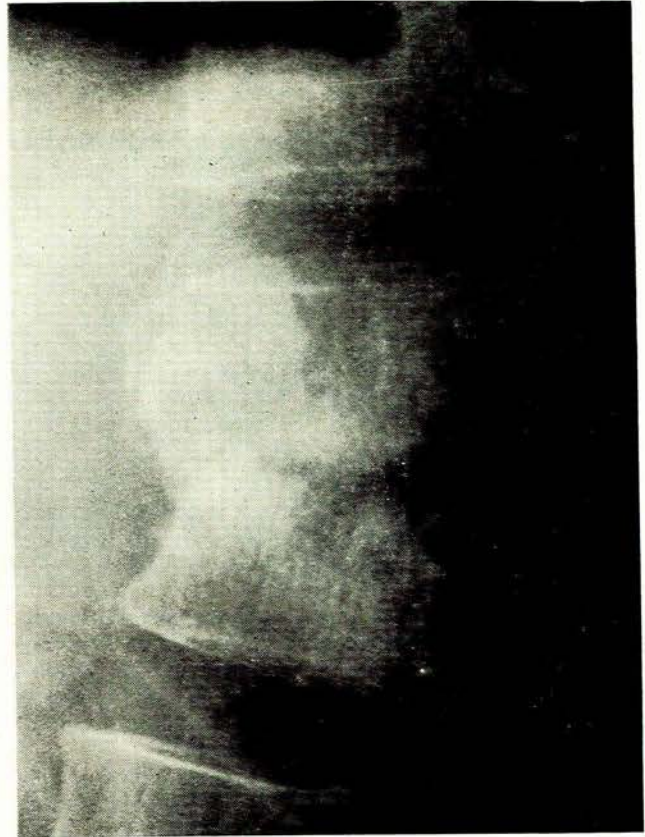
Lateral X-ray of the spine taken 4 weeks after anterior fusion. Bony fusion between the two involved vertebrae is taking place.
